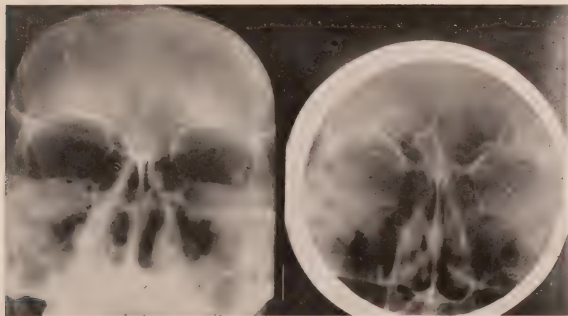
Roentgenogram of accessory sinuses at angle of 23° showing the shadow of the petrous portions of the temporal bones partially obscuring the shadows of the Antra.
